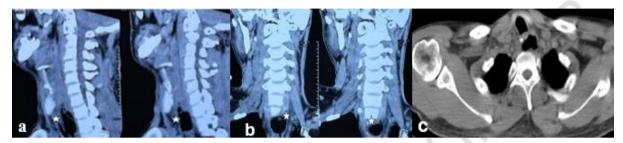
(a), (b) CT scan of sagittal and coronal views showing the foreign body (bottle cap) noted in the upper oesophagus at the level of C6 and C7 vertebrae which is seen impinging the posterior wall of trachea. (c) Axial cut of CT scan showing foreign body posterior to trachea.
